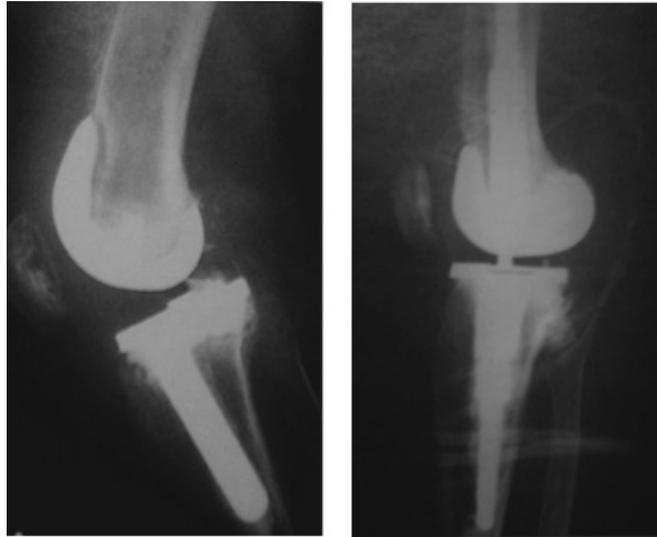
Radiographic images of an infected knee arthroplasty. Image on the left shows femoral periprosthetic radiolucency and periosteal growth, indirect signs of infection; while the right image shows the postoperative control after the replacement.
